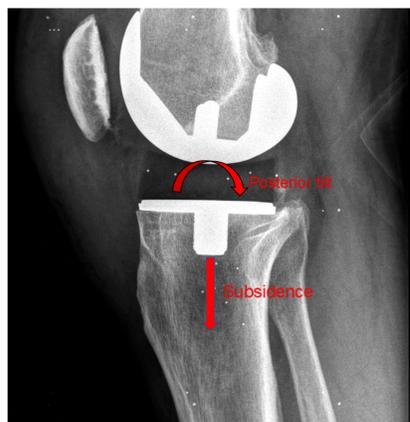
X-ray of cementless TKA. Arrows indicate the predominant migration directions of cementless tibia component. Curved arrow: Posterior tilt. Straight arrow: Subsidence.
